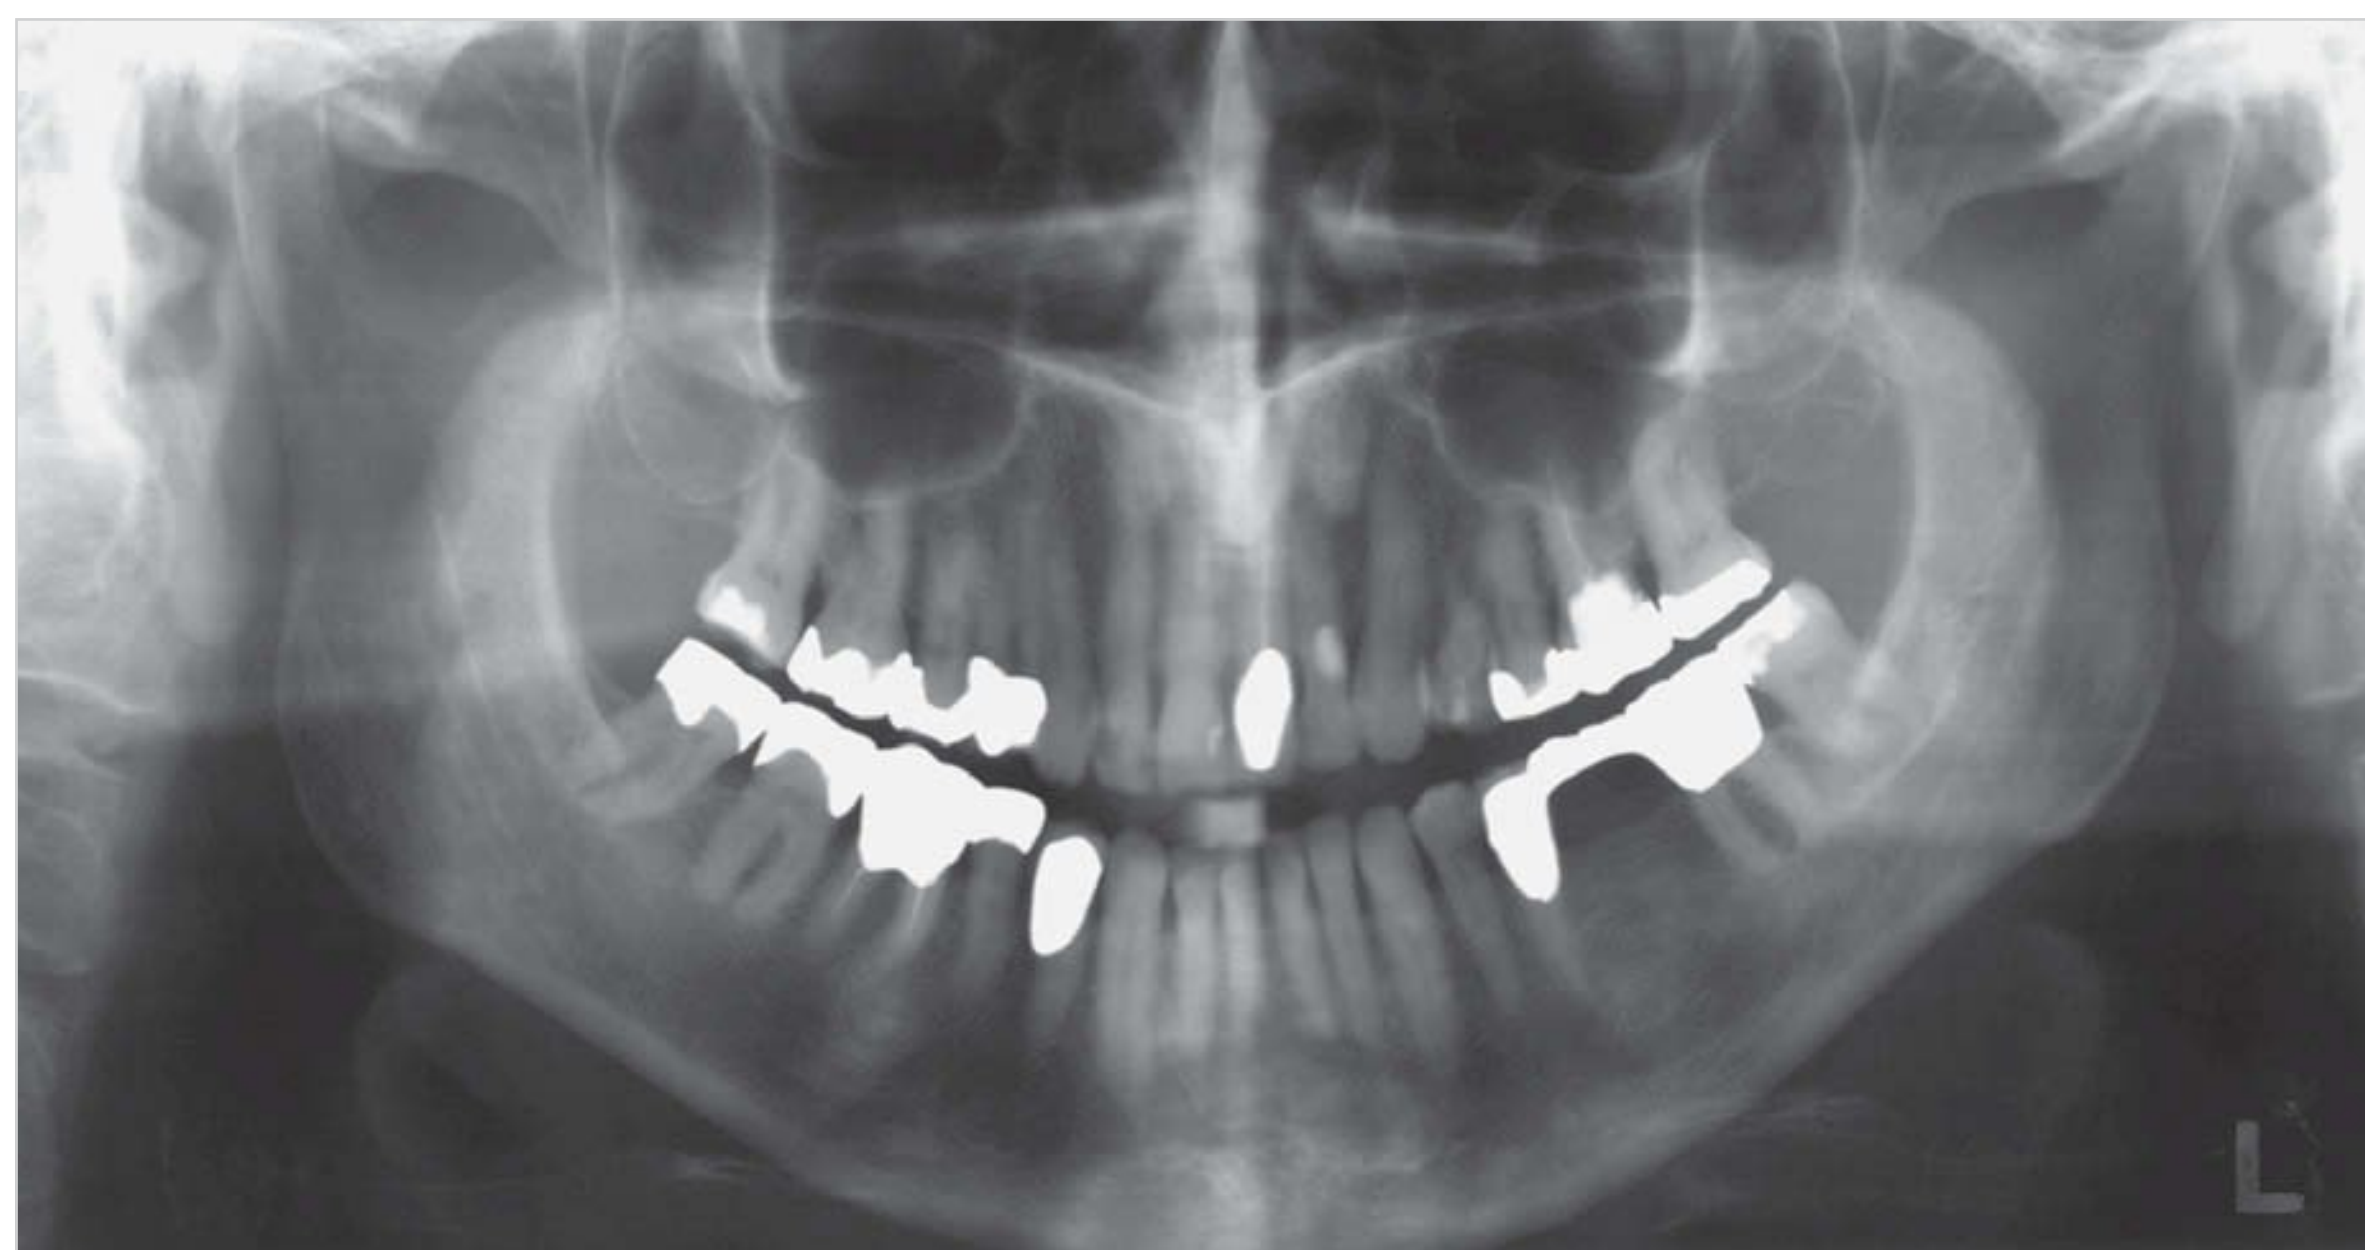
Panoramic radiograph taken with the head tilted forward.
